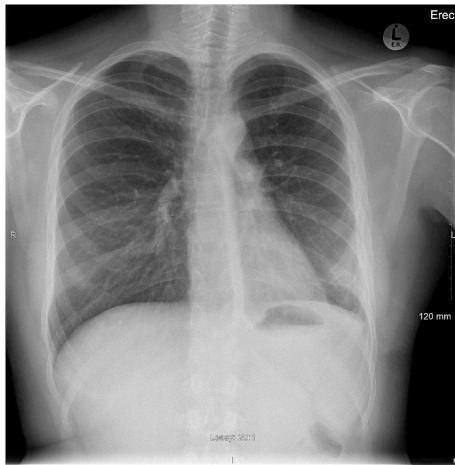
Erect chest radiograph at 6-month follow up showing resolution of hydropneumothorax and minimal residual pleural change on right side.
